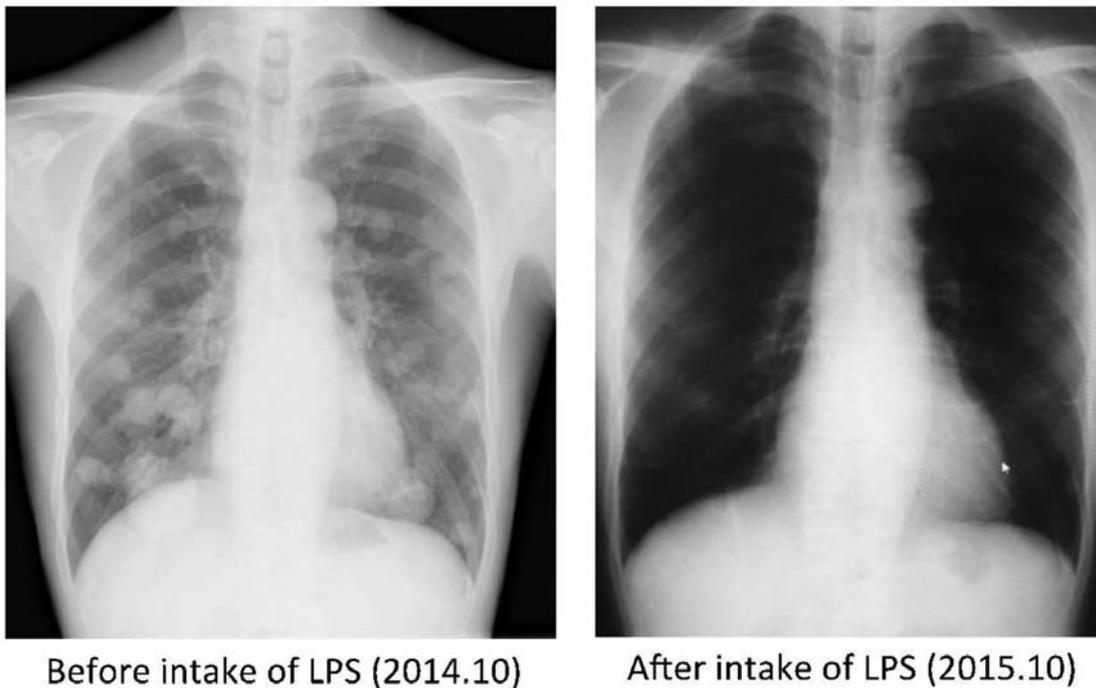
Comparison of lung X-ray picture before and after oral administration of LPS. The right picture shows the complete regression of multiple metastatic lung tumors (Male, 66-year-old, administered 1.25mg/ day of LPS for 10 months).
